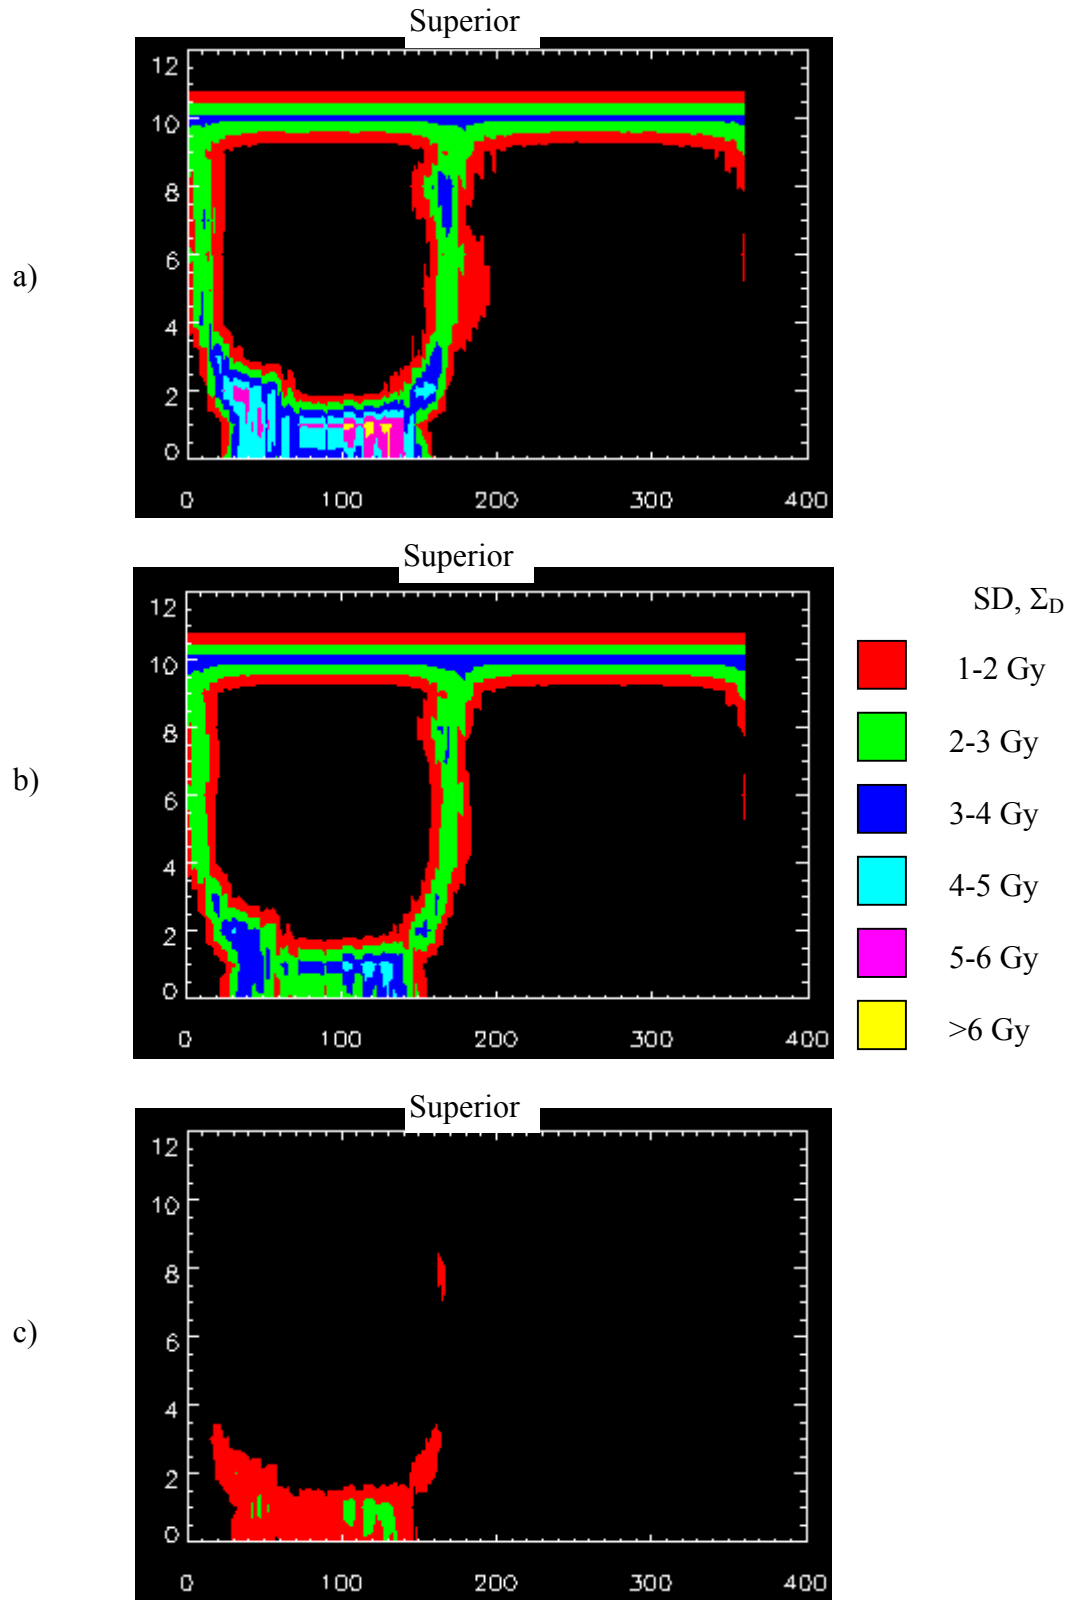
The standard deviation in dose presented as a DSM. A margin of 15 mm is used with a) one, b) two, and c) an ‘infinite’ number of pretreatment CT scan information. Orientation: Left=0°; Anterior=90°.
